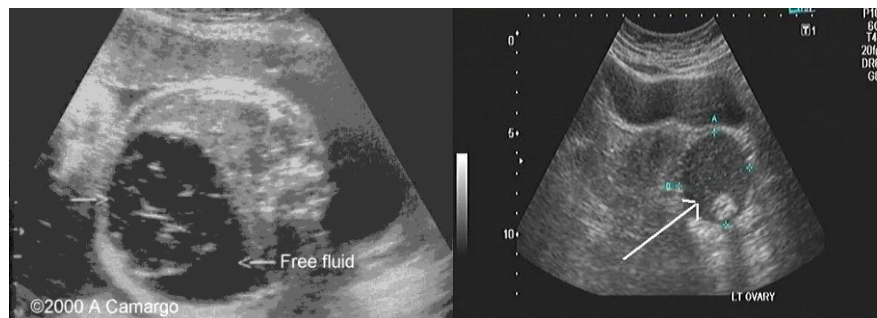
ultrasound image for ovarian teratoma (Rumak,c.et al 2011)
